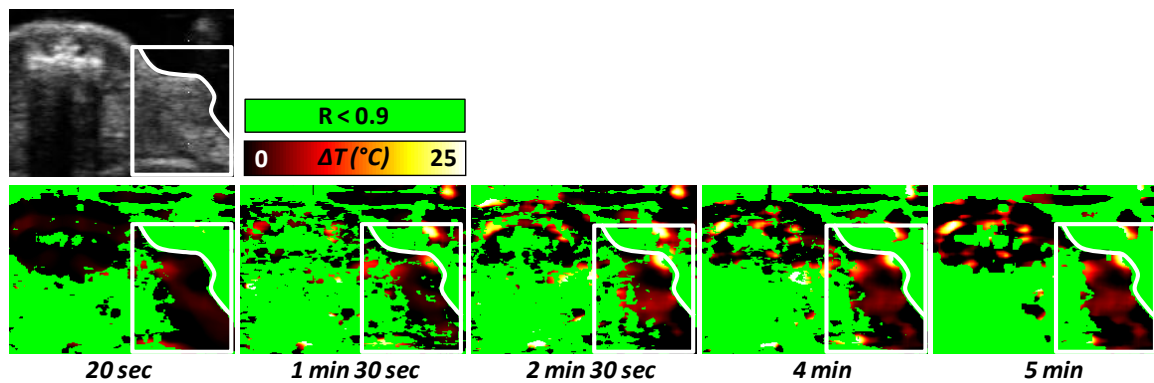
Temperature estimation by ultrasound-based thermal imaging.
